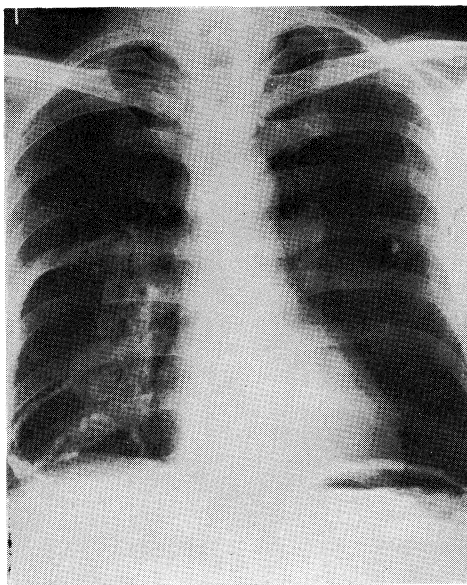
Chest X-ray film, showing a calcified infiltrative shadow in the broad zone of the right lung.
